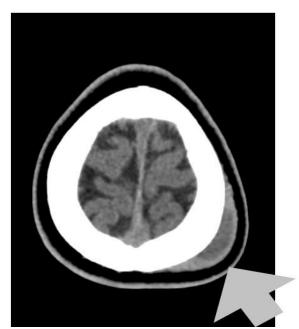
Computed tomography scan of head (sagittal view) showing subgaleal haematoma in right parietal region (arrowed) in 9-year-old SCA girl.
